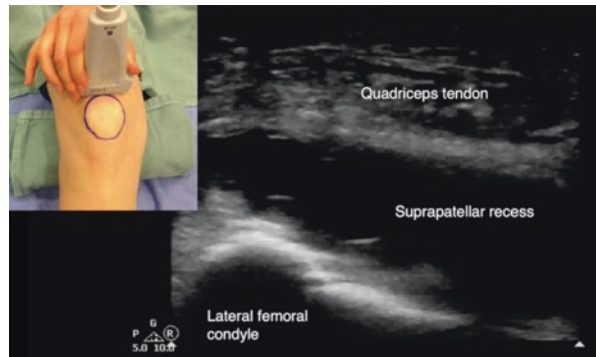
Sonographic image of the probe position ready for injection. (Reprinted with permission from Philip Peng Educational Series)
